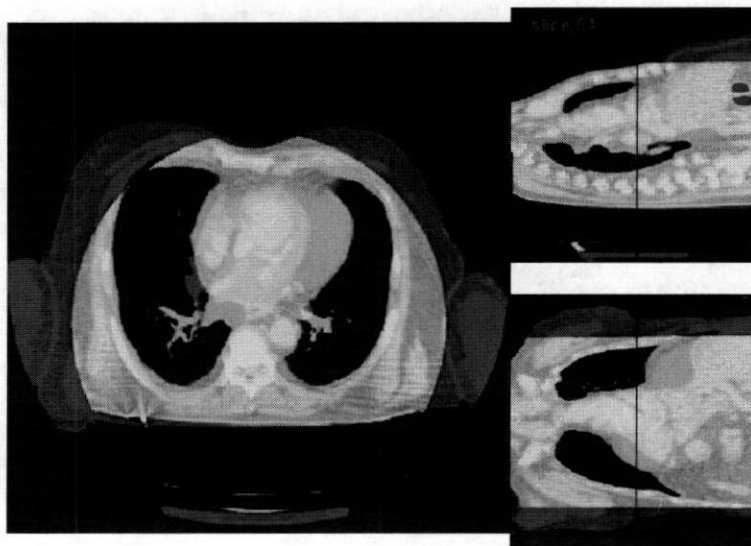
Overlapped orthogonal views of the intra-fraction CT images. The red component is the inhale image, which is used as reference image. The green component is the exhale image, which is used as test image.
